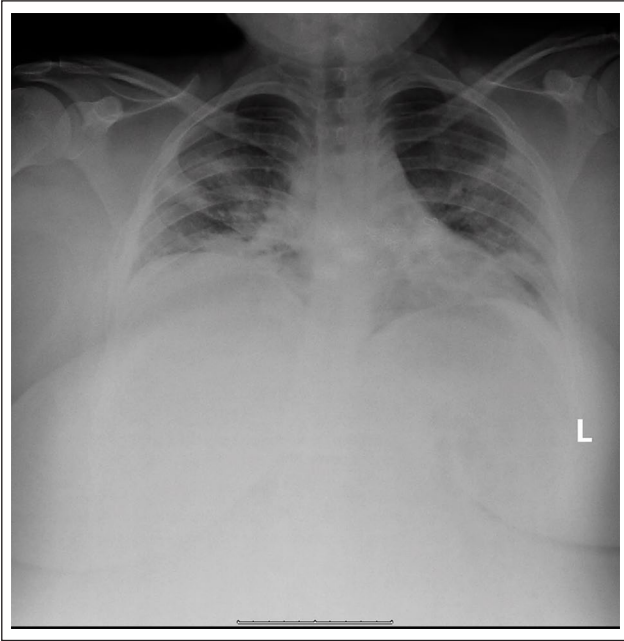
AP chest X-ray, 19-year-old female, bilateral patchy infiltrates.
